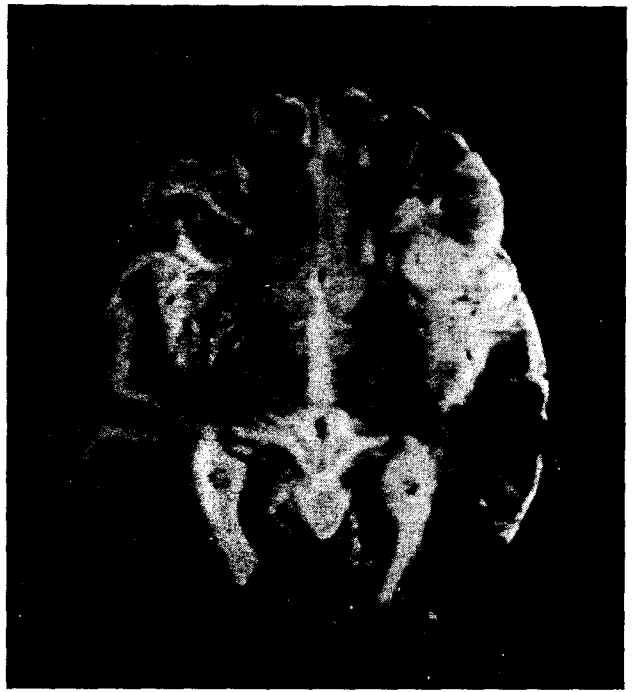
MRI of patient with a lesion principally confined to the left insular cortex
